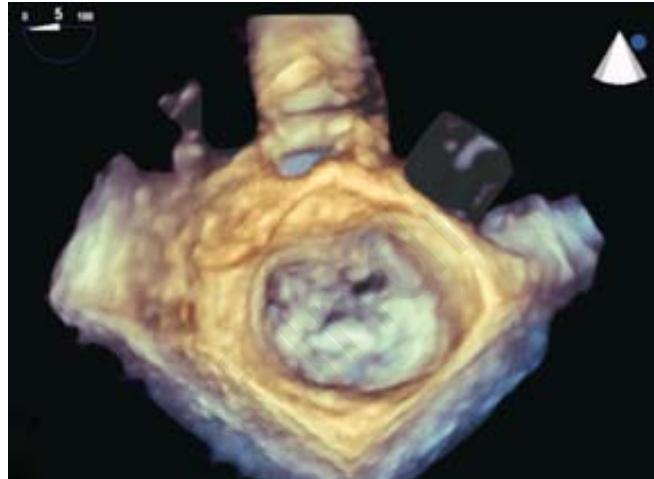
Surgeon’s vision or *en face* view using three-dimensional transesophageal echocardiogram.
